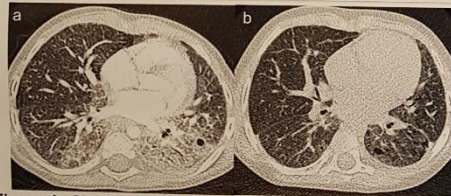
Chest-CT scan performed in P1 before (a) and one year after (b) introduction of ruxolitinib.
